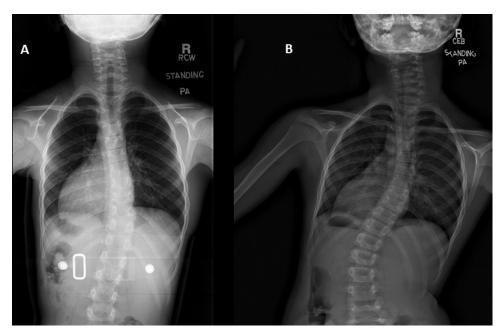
Figure (A) and (B) X-ray showing progressive scoliosis.
